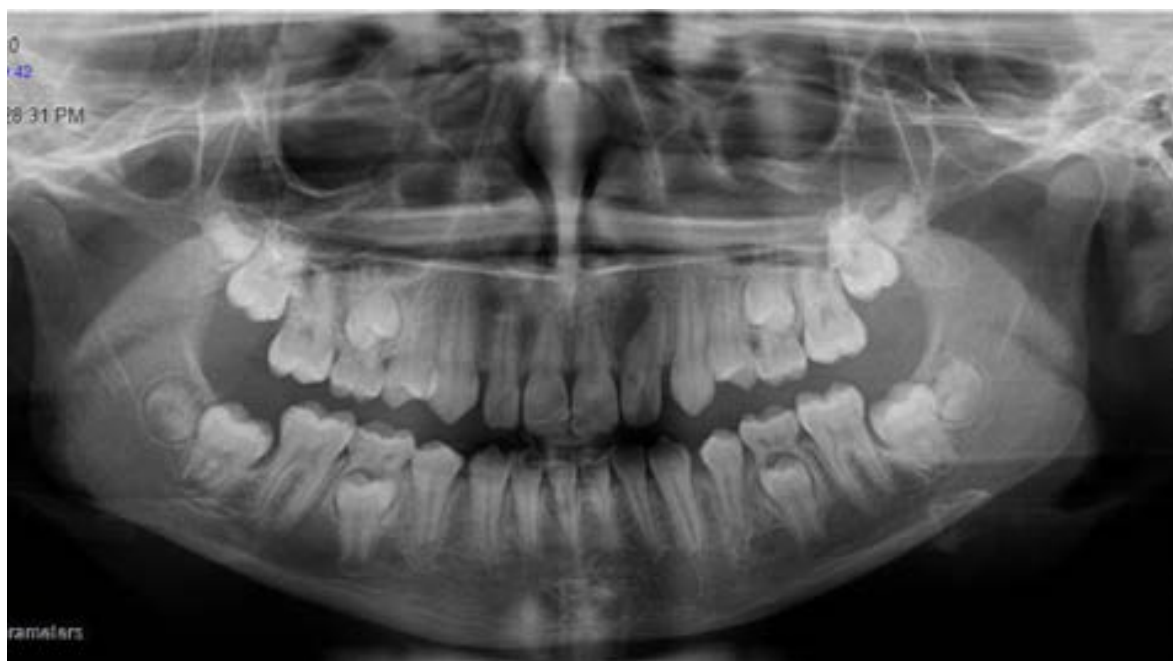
Oehlers Type II Dens Invaginatus in maxillary left lateral incisor on panoramic x-ray
